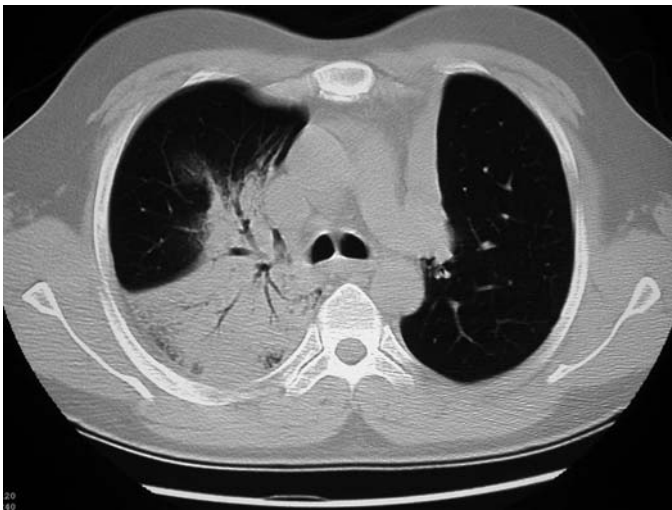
FIGURE e28-4 Computed tomography of the chest demonstrating a dense infiltrate with air bronchograms involving a segment of the right upper lobe due to bacterial pneumonia in an immunosuppressed patient with Wegener's granulomatosis. Collapse of the left upper lobe secondary to endobronchial stenosis from Wegener's granulomatosis also is seen on this image.
